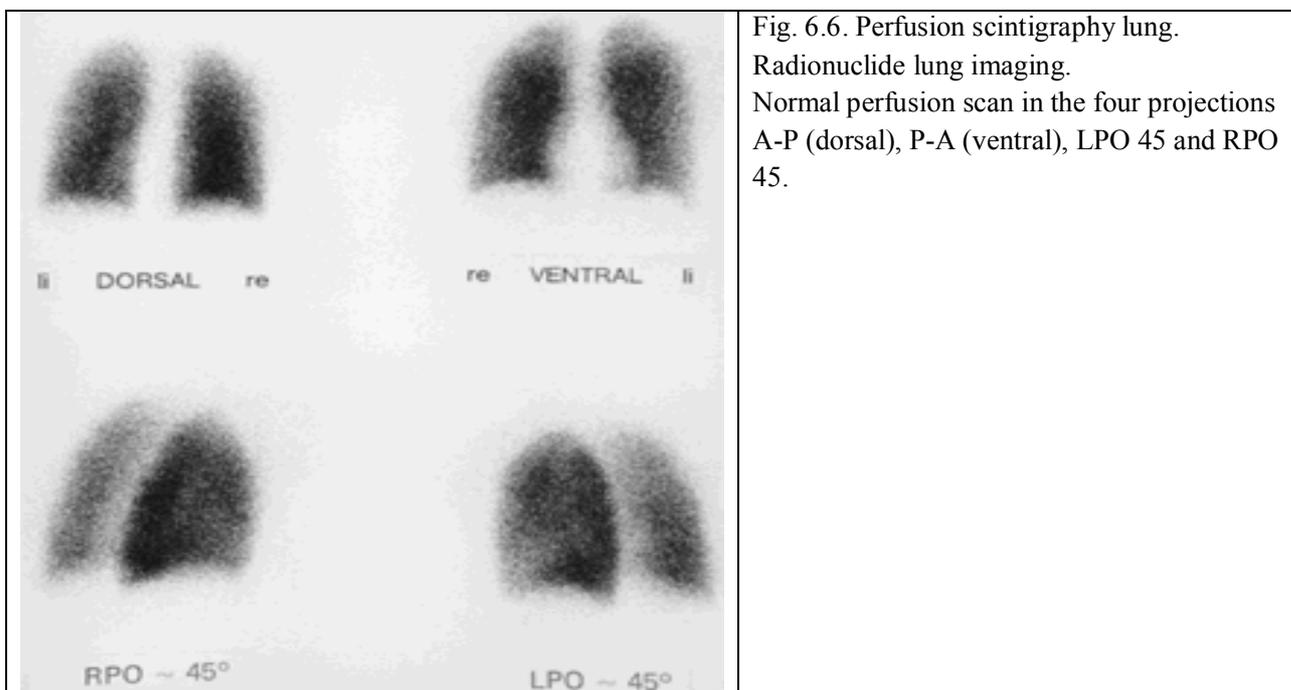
Perfusion scintigraphy lung. Radionuclide lung imaging. Normal perfusion scan in the four projections A-P (dorsal), P-A (ventral), LPO 45 and RPO 45.
